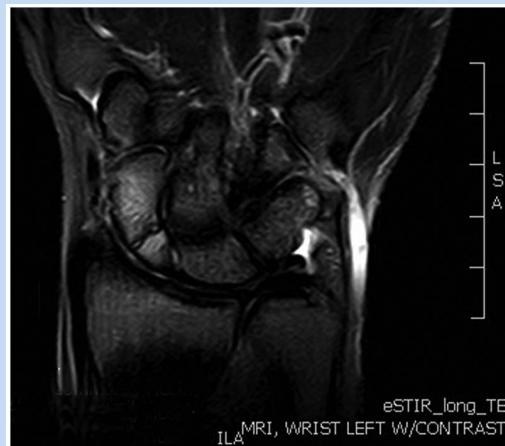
MRI with contrast (coronal image [short-tau inversion recovery]), which depicts a nondisplaced waist fracture of the scaphoid.
